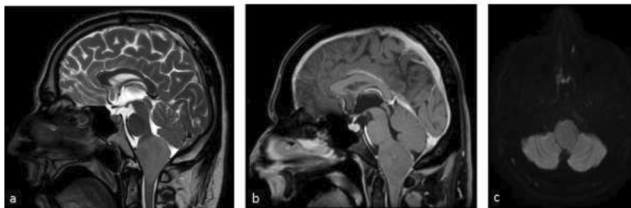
Bulbar lesion, Male patient, 27 years old. a) Sagittal T2-weighted MRI image, b) Contrast-enhanced sagittal T1-weighted MRI image, c) Axial Diffusion-Weighted Image
